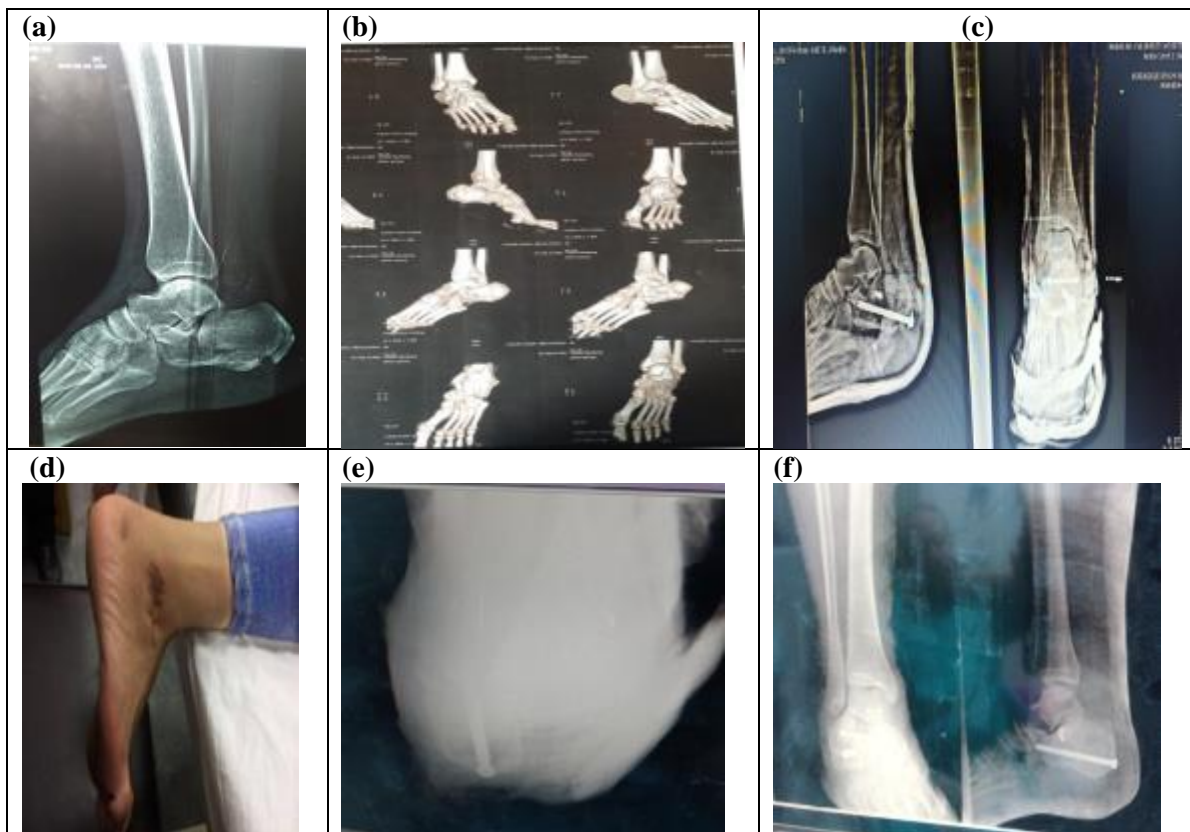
A 45 years old female falling from height was admitted to Hospital 2 days following the trauma; (a,b) pre-operative radiographs; (c) Immediate post-operative; (d) Non weight bearing with crutches was started after 3rd post-operative week and (e, f) final radiographs. Final clinical evaluation revealed that patient was graded excellent with functional score (90).
